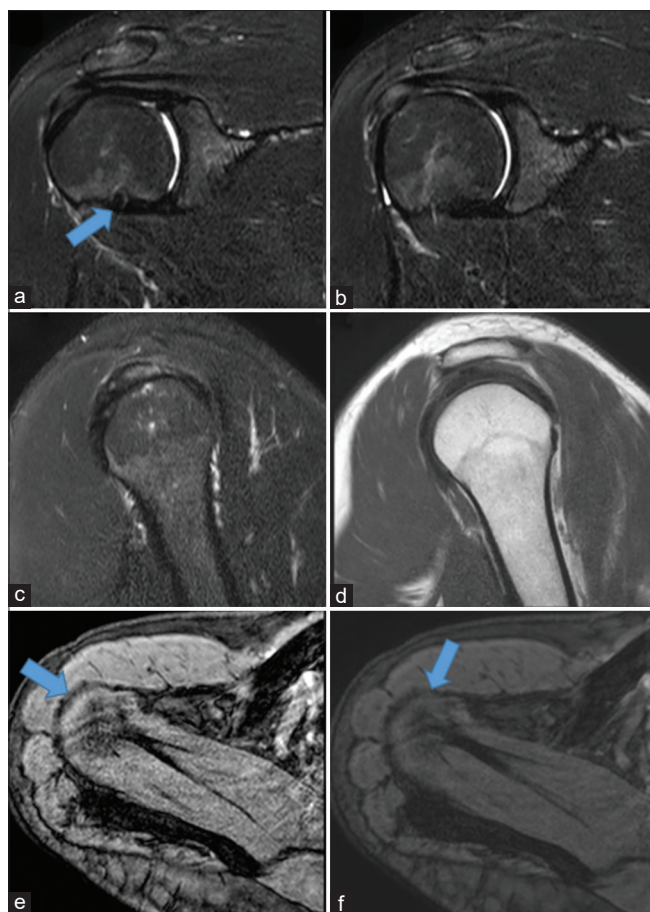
Sectional magnetic resonance imaging of the shoulder. (a) Coronal section view of the humeral head. (a) Biceps tendon was created with the blue arrow, (b-d) the rotator cuff is shown and intact, (e and f) an axial section view of the shoulder, and blue arrows indicate the rotator cuff attachment site
